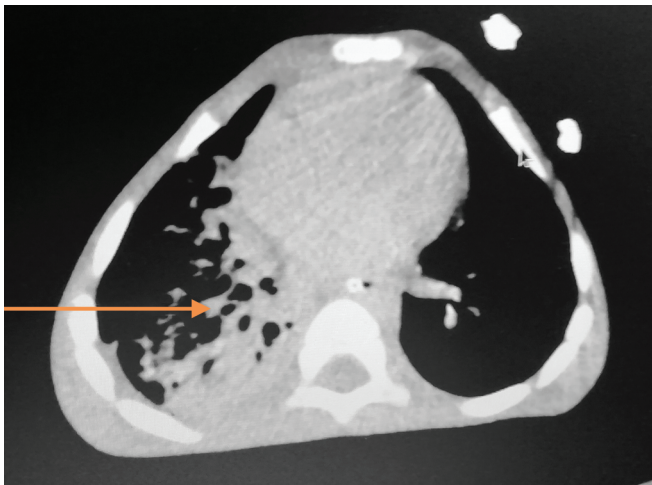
CT thorax showing right lung centrilobular opacities
